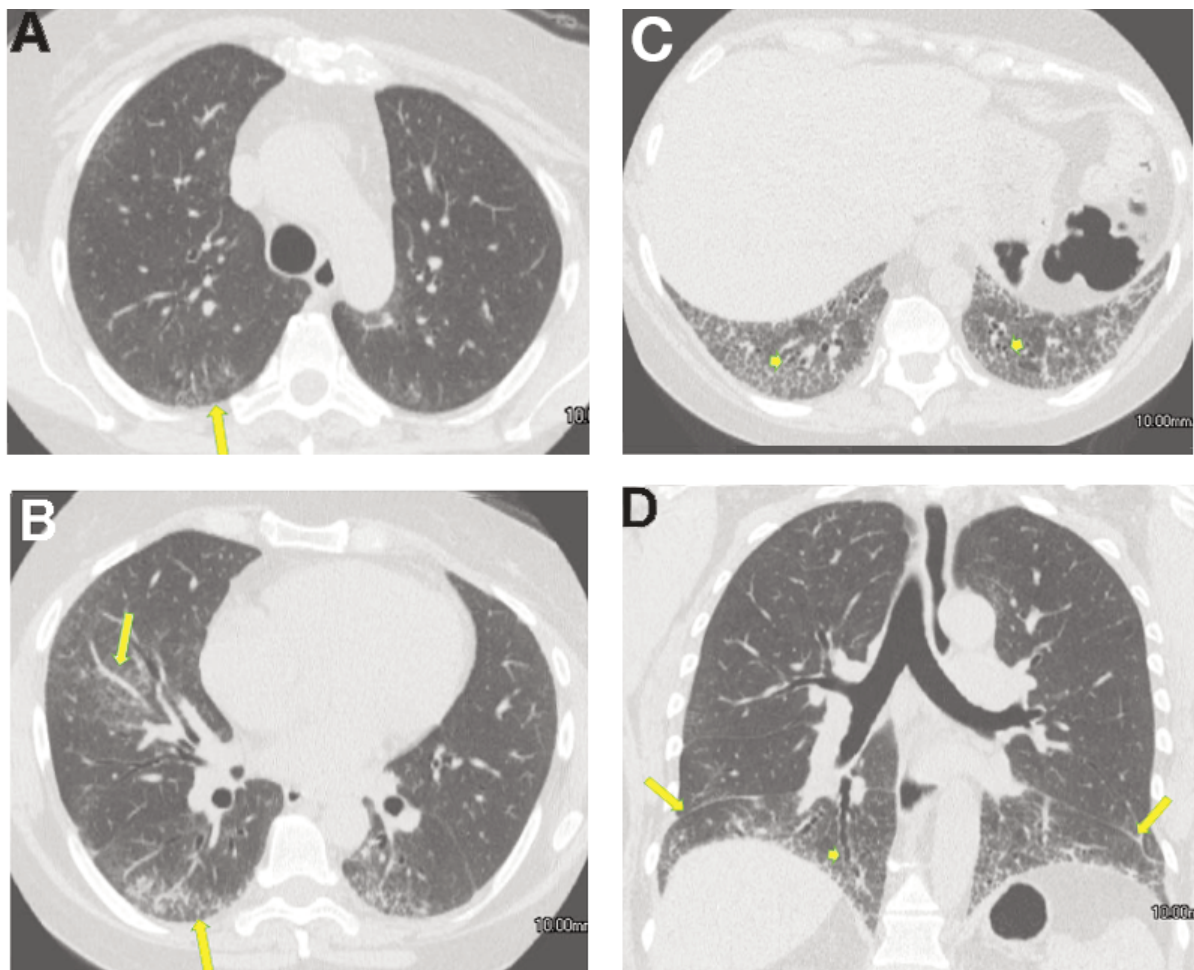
HRCT images at presentation in a patient with SSc-ILD. Axial image at the level of the aortic arch (A), axial image at the left inferior pulmonary vein ostium (B), axial image just above the hemidiaphragms (C), and coronal image (D) demonstrating the cranio-caudal distribution of disease. Note the ground glass densities (arrows in A and B) with mild involvement of the upper lobes but progressively more severe involvement towards the bases. Extensive reticulation is seen in the bases with mild traction bronchiectasis/bronchioloectasis (arrowheads in C). Sparing of the immediate subpleural lung is best seen posteriorly on the right in B. Basilar predominant ground glass densities with traction bronchiectasis and subpleural sparing is typical of an NSIP pattern of lung injury. In the coronal HRCT image, unlike a UIP pattern of lung injury, NSIP shows a more homogenous basilar predominance and does not extend up the lateral sidewall. Note the volume loss characterized by the downward fissural displacement (arrows in D) as well as the traction bronchiectasis (arrowhead in D).
